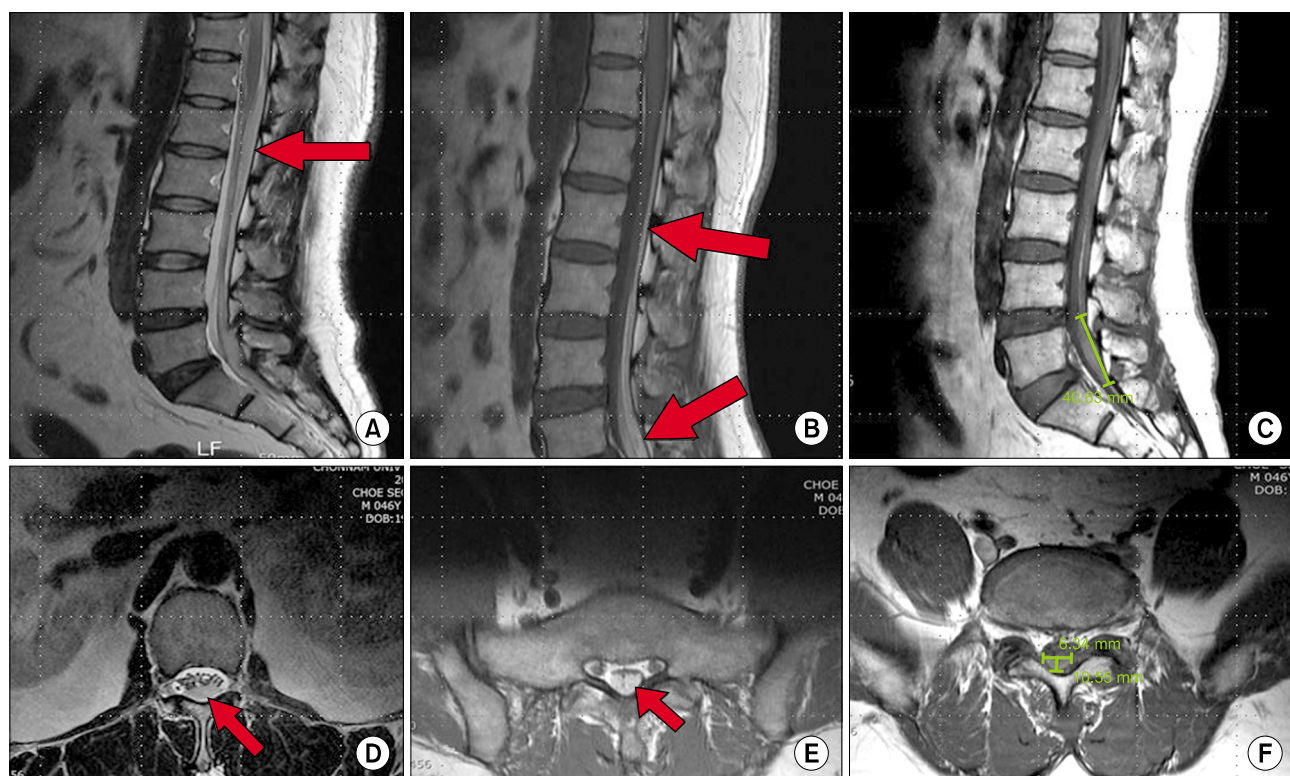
Thoracic spine MRI (Feb 9 2018) showed suspicious subdural hematoma of L1-L2 and causing moderate central spinal stenosis (A). Follow-up thoracic spine MRI (Feb 14 2018) showed subdural hematoma of T12-S2 causing moderate to severe central spinal stenosis of L5-S2 (B). Follow-up thoracic spine MRI (Mar 12 2018) showed decreased subdural hematoma of L4-S1 (C) and the axial image of MRI (D, E, F).
